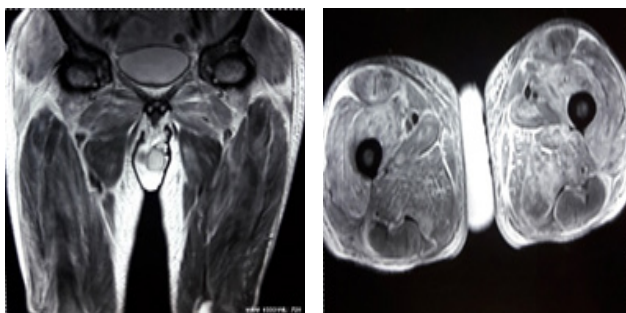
MRI of thigh muscles
